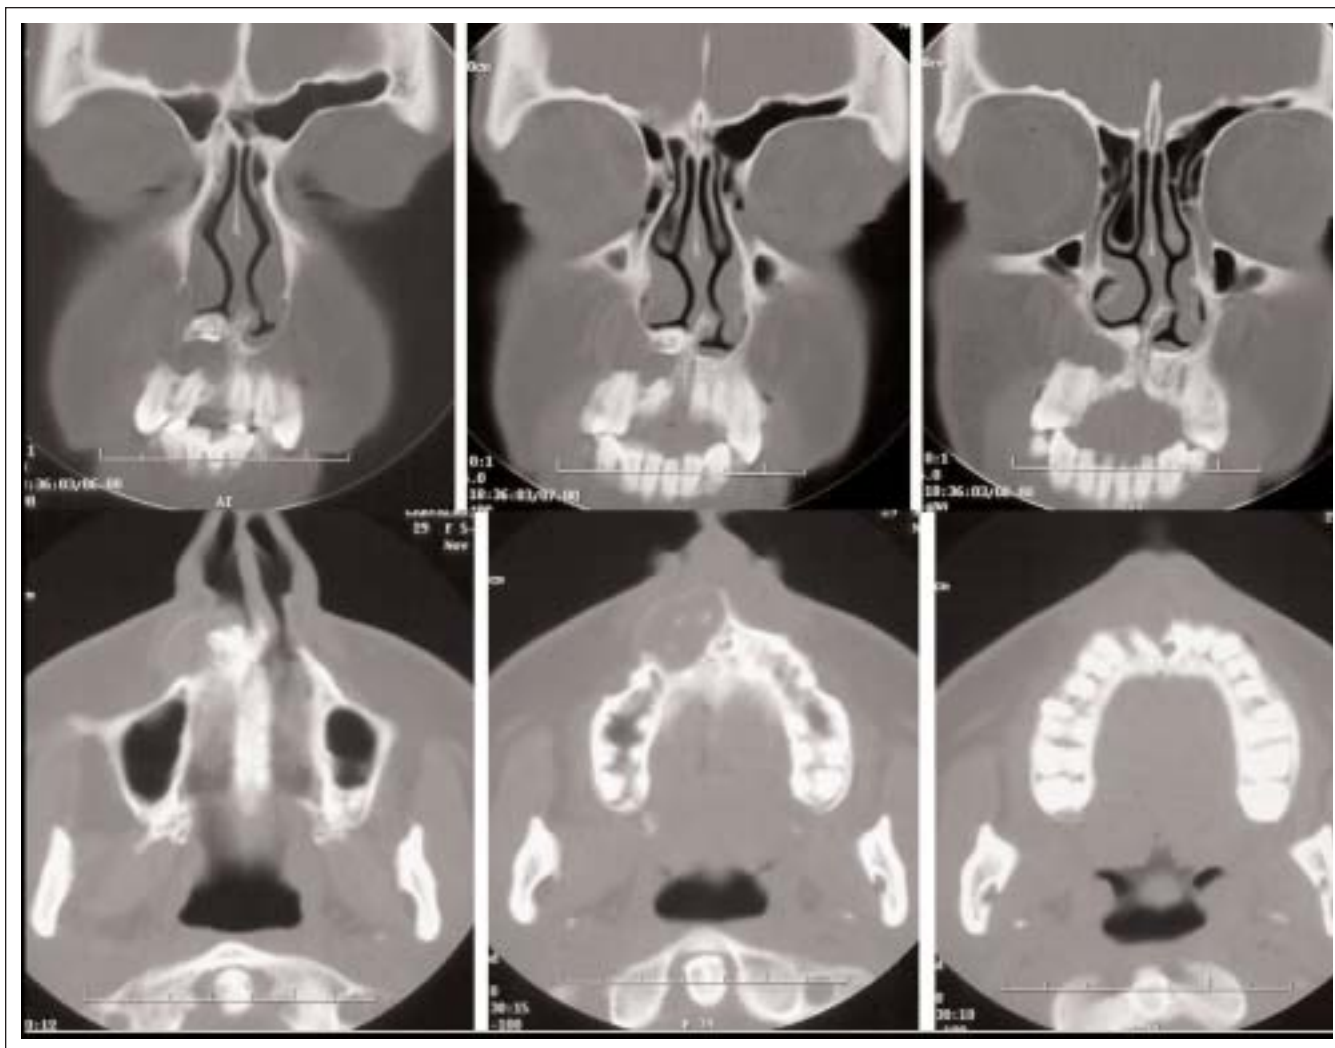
Preoperative Computed Tomographic (CT) Exams – Coronal and Axial CT showing the presence of the osteolytic lesion, with a “tumor-like” pattern with cortical expansion and a focal radiodense area into the lesion
